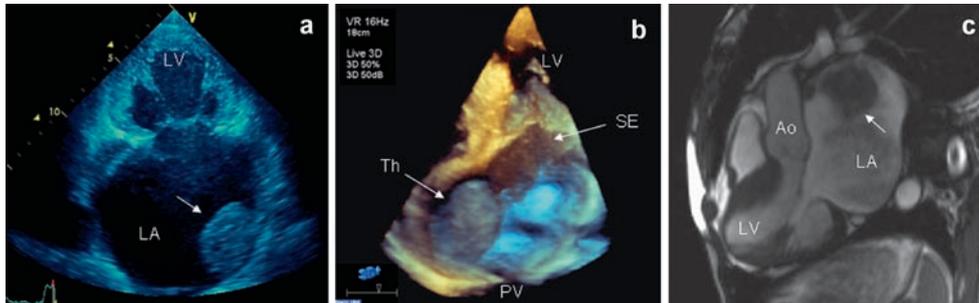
Left atrial thrombus in a monstrous dilated atrium (10.0 × 10.5 cm) in a 46-year-old male patient with long-standing hypertrophic restrictive cardiomyopathy. Transthoracic echocardiographic imaging (a) shows the isodense appearance of the large immobile thrombus (4 × 5 cm) (arrow) broadly attached to left atrial wall. Note the marked spontaneous echo contrast (SE) passing from
